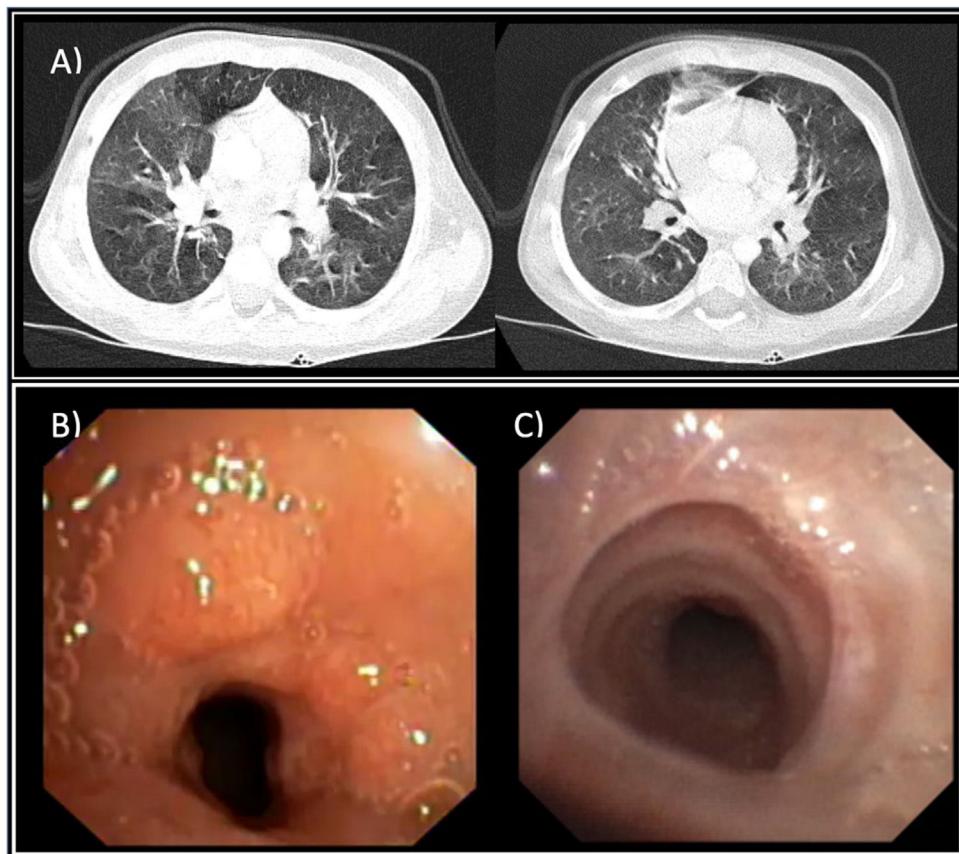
(A) Lung computed tomography scan: bilateral mosaic attenuation pattern compatible with bronchiolitis obliterans. (B) Flexible bronchoscopy: tracheal stenosis with reduction of 60% to 70% of the tracheal lumen due to granuloma. (C) Flexible bronchoscopy, 3 months after image B: residual membrane after steroid therapy and dilations.
